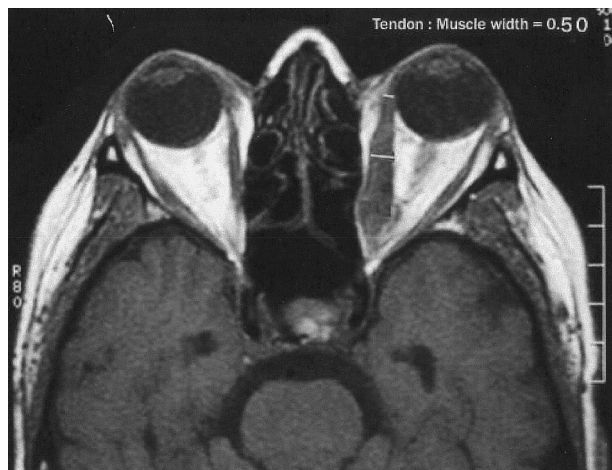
Moderate to severe involvement of muscle tendon on magnetic resonance imaging scan of a patient with thyroid-associated orbitopathy (fusiform enlargement, tendon/muscle ratio 0.50).
